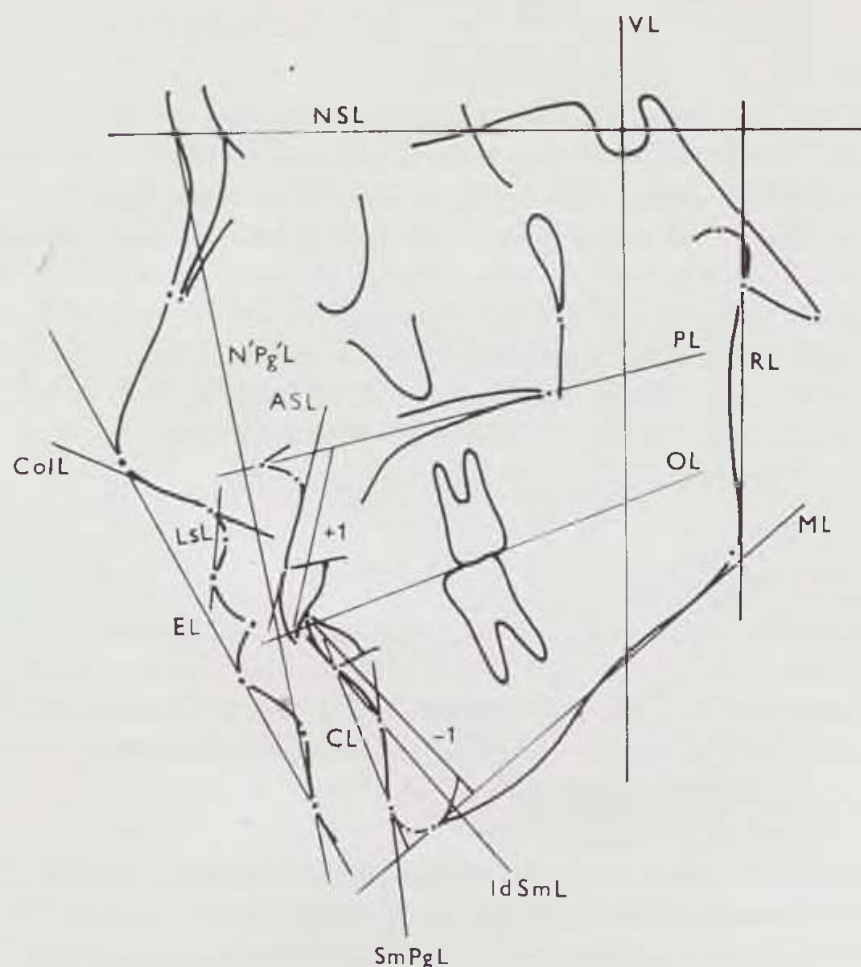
Reference lines used for the assessment of X-ray films: NSL=line through N and S, VL=perpendicular to NSL through S, PL=line through Sp and most posterior point of the palatal processes, OL=line through midpoint between Is and li and through midpoint between the distobuccal cusp of the first upper and lower molar, ML=tangent to the mandibular body through Gn, RL=tangent to the upper alveolar process through Pr, SmPgL=line through Sm and Pg, IdSmL=line through Id and Sm, +1=axis of the upper central incisor -1=axis of the lower central incisor. N'Pg'L=line through N' and Pg', EL=line through Prn and Pg', ColL=tangent to the columella through Sn, LsL=line through Ls and midpoint between Sn and Ss', tGo=point at the intersection of ML and RL (tangentia gonion point).
